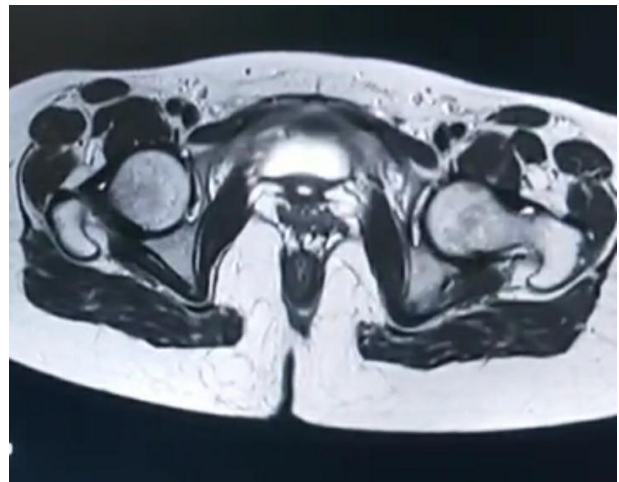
MRI Pelvis - T2 hyperintense images.
